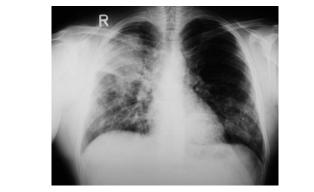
Chest X-ray showing bilateral pneumonia that was worse on the right side.
